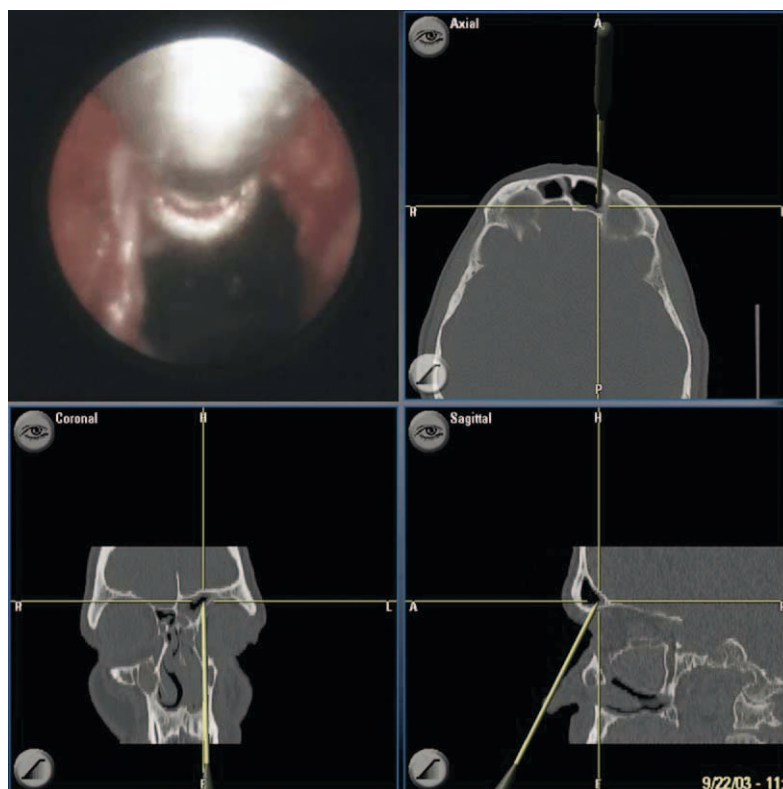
Intraoperative screenshot of the navigation system: Endoscopic picture of the SCD 6000 enlarging the frontal sinus ostium (upper left) with corresponding axial, coronal, and sagittal CT sections.
